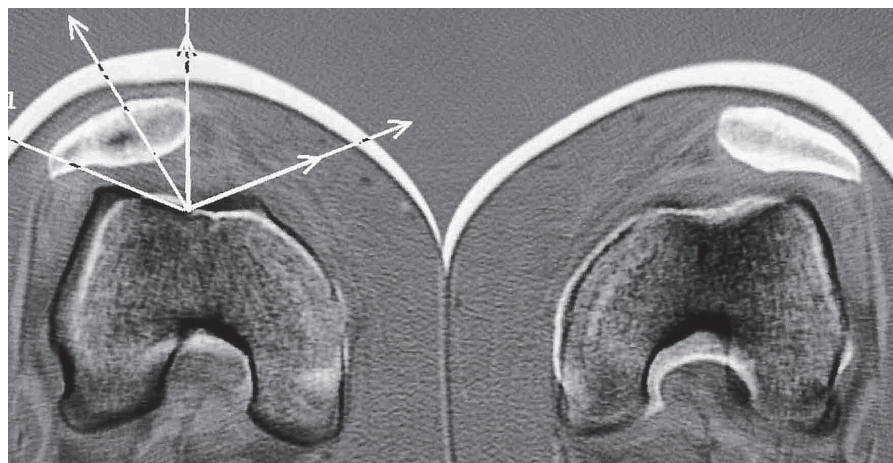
CT at 0° from a patient with severe anterior knee pain and patellofemoral instability in the left knee (a). This knee, which was operated on 2 years ago, performing an Insall's proximal realignment, was very symptomatic in spite of the correct patellofemoral congruence. Fulkerson test for medial subluxation was positive. Nevertheless, the right knee was asymptomatic despite the PFM. Conventional radiographs were normal and the patella was seen well centered in the axial view of Merchant (b). Axial stress radiograph of the left knee (c) allowed us to detect an iatrogenic medial subluxation of the patella (medial displacement of 15 mm). Note axial stress radiograph of the right knee (d). The symptomatology disappeared after surgical correction of medial subluxation of the patella using iliotibial tract and patellar tendon for repairing the lateral stabilizers of the patella
